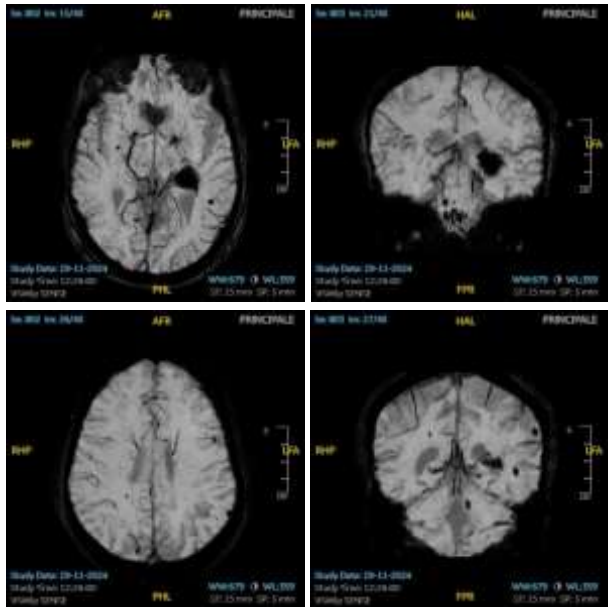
MRI imaging study (SWI sequences) showing multiple cerebral angiomas in left temporal and parietal lobes, basal ganglia, left cerebellar hemisphere, and brainstem in our patient.
